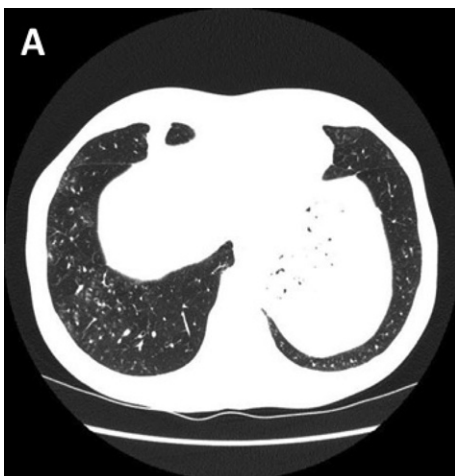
CT-scan; basal section showing bronchiolitis and a diffuse mild micronodular pattern.
